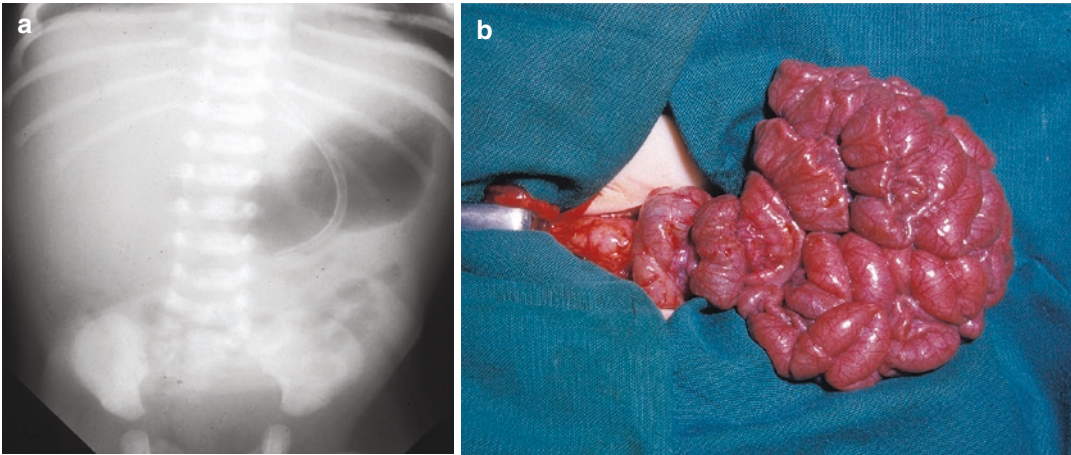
(a, b) Featureless abdominal X-ray indicative of midgut volvulus
